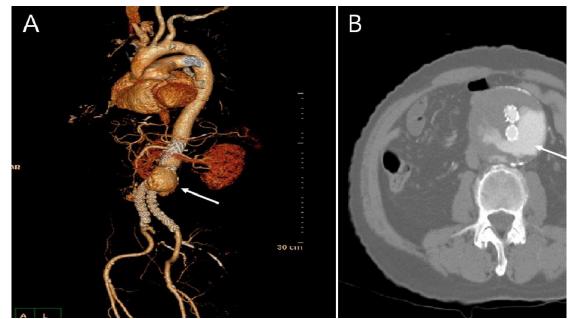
Post-operative computed tomography (CT) showing an abdominal aortic aneurysm (A, white arrow) and a Type Ia endoleak (B: white arrow)
